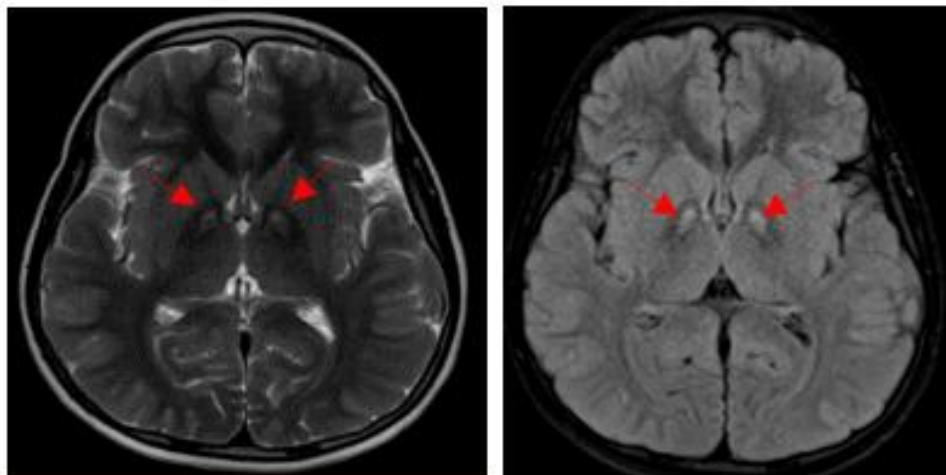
T2 weighted and fluid attenuated inversion recovery sequence (FLAIR) demonstrates symmetrical central hyper intensity surrounded by hypointense signal in globus pallidus, consistent with the Eye-of-the-tiger appearance [red arrows]
